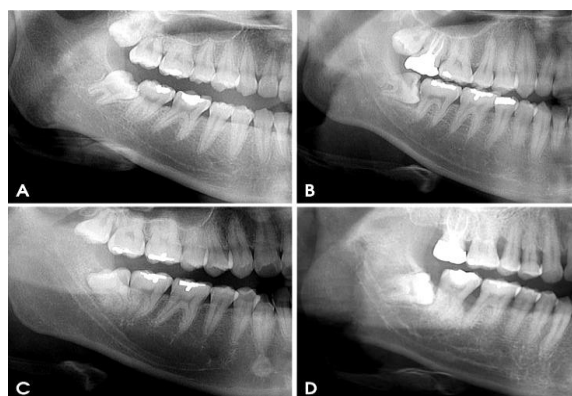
Classifications of the course of the mandibular canal on panoramic radiographs: A- Linear curve, the canal curve is approximately a straight line; B- Elliptic curve, the curve is approximately symmetrical; C- Spoon-shaped curve, the canal has an approximate spoon shape that is similar to an asymmetric elliptic arc; and D-Turning curve, the course is unsmooth and has a turning point¹⁶.
